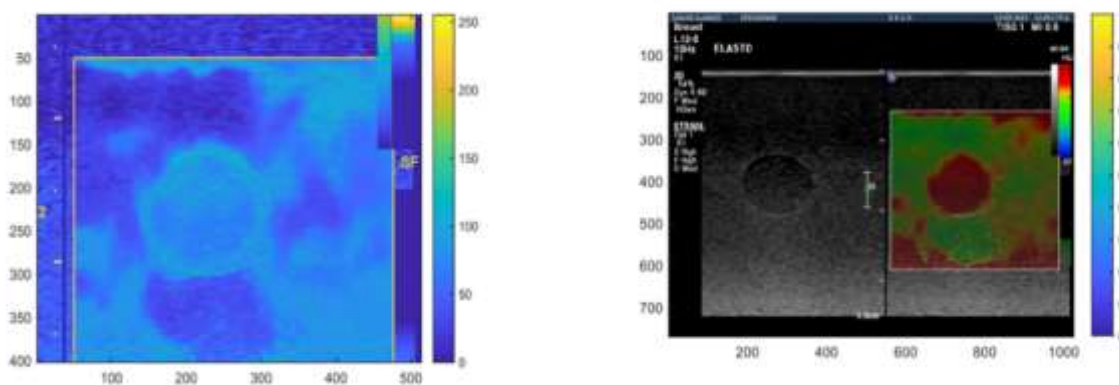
the Ultrasound images on the left side obtained through matlab and the on the right side obtained from the scanner.
